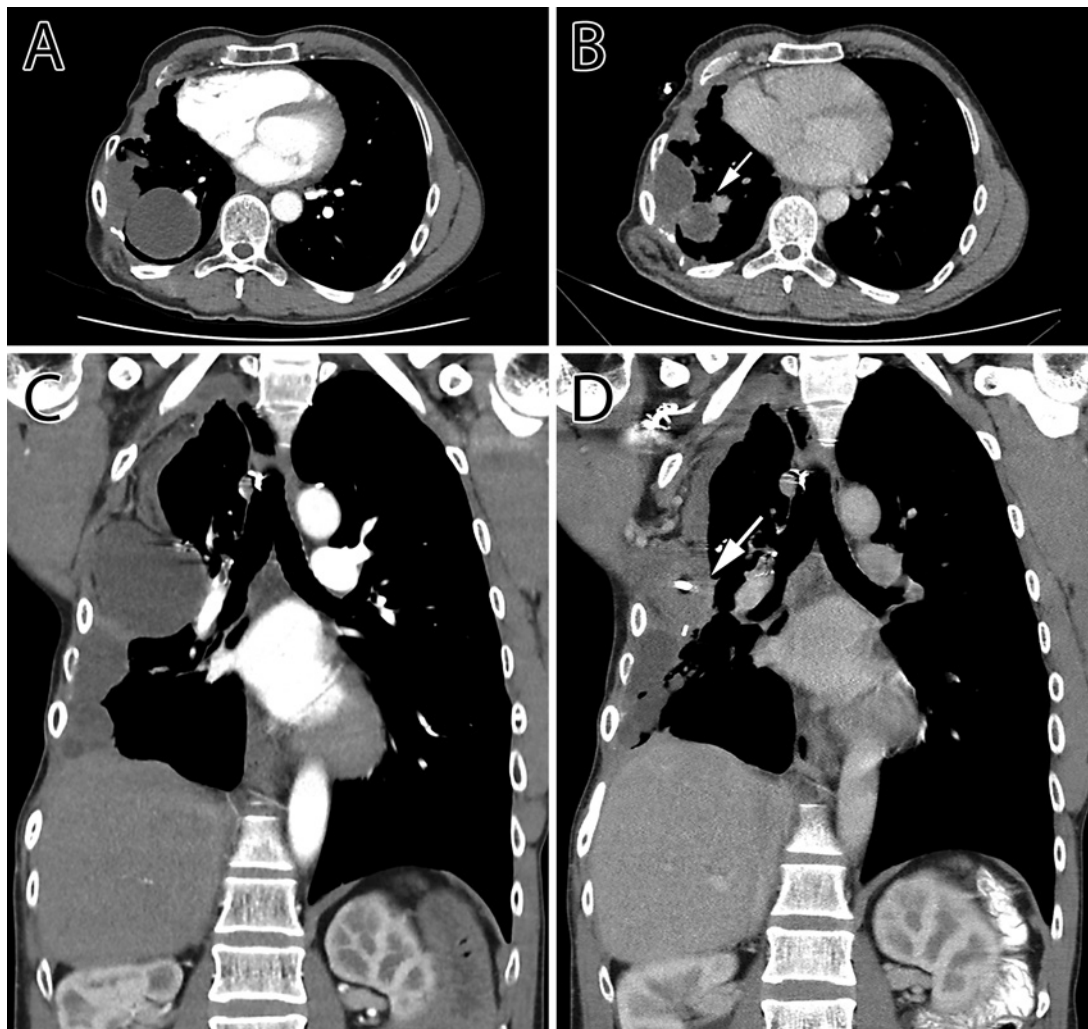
Pre-treatment (A, C) computed tomography sections of significant loculated pleural recurrence from PMP disease in a 41-year-old male. Day 16 (B, D) post-BromAc® treatment progress images demonstrating reduction in size of previous mucinous mass as indicated by the white arrows.
